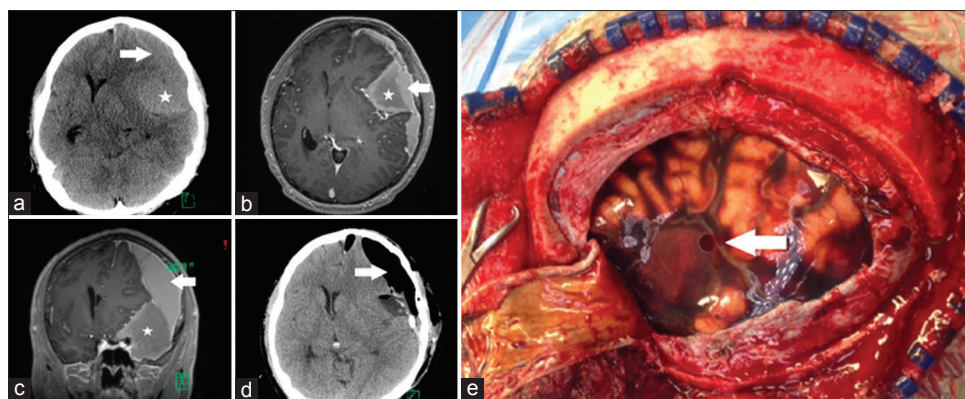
Noncontrast computed tomography and magnetic resonance imaging of the brain demonstrating a large subdural hematoma (arrow in images) (a-c) along with a separate collection 3.7 cm in width along the left sphenoid wing of the lateral ventricle, (star in images) (a-c) consistent with an arachnoid cyst with intracystic blood and surrounding subdural hematoma. (d) Postoperative computed tomography demonstrating interval improvement in midline shift following the evacuation of the hematoma. (e) Intraoperatively, a middle cranial fossa arachnoid cyst with significant hemorrhage and a small hole (arrow) communicating with the subdural space were visualized
